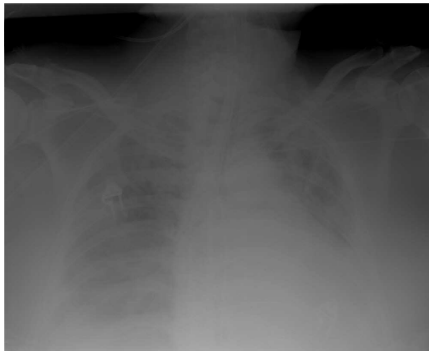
The original X-ray chest image.
